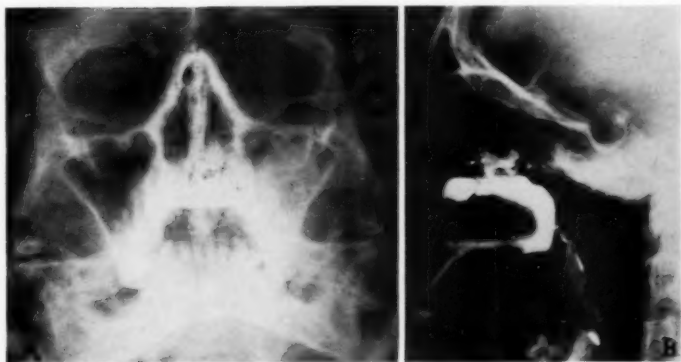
Case I. A) X-ray (Waters view) reveals a large cyst almost completely filling left maxillary sinus. B) Lateral view depicts the filling defect.
